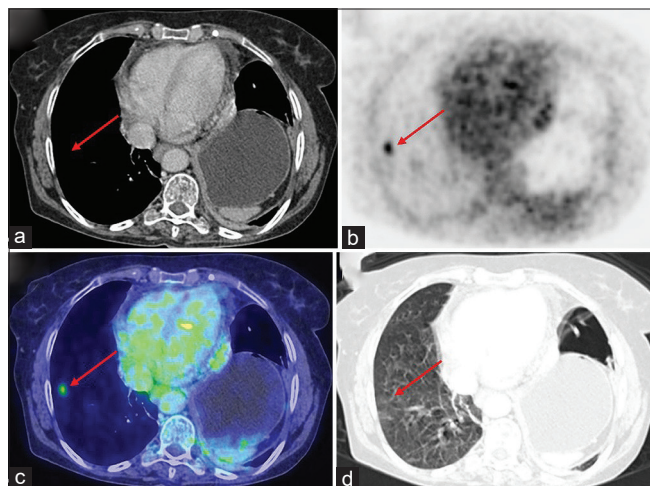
CT scan image (a), MIP image (b), axial fused image (c), and axial CT scan image in lung window (d) from FDG PET/CT of 72 years female showed an unusual hypermetabolic focus in the lateral basal segment of right lower lobe without any focal lesion in mediastinal as well as lung window (red arrow), suggestive of FDG-avid microembolus.
